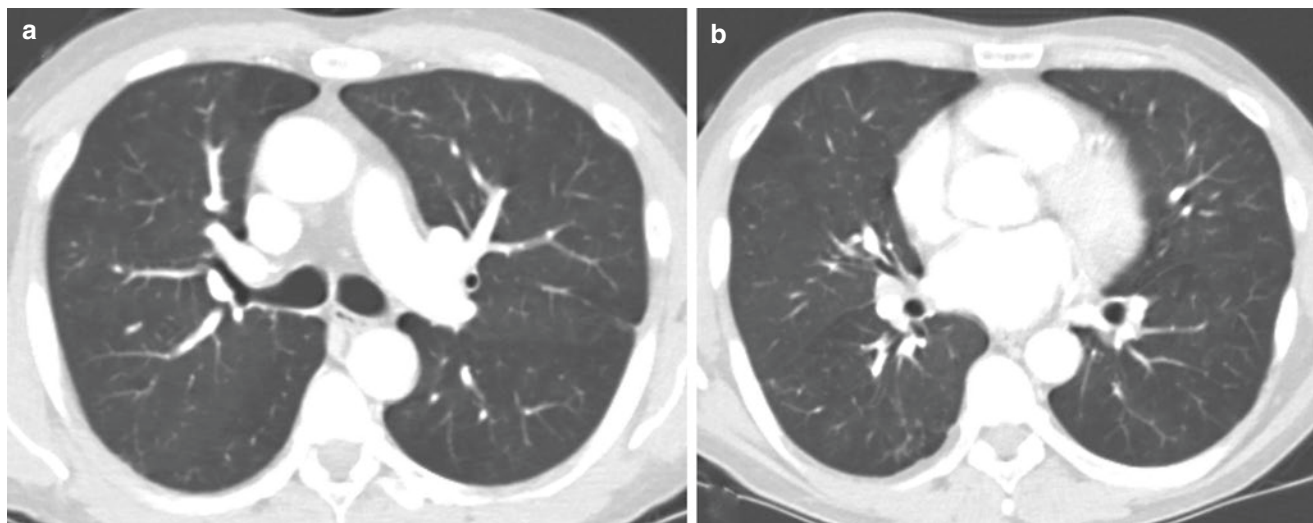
(a, b) Chest CT images performed after 1 year of immunosuppressive treatment showing resolution of alveolar opacities
